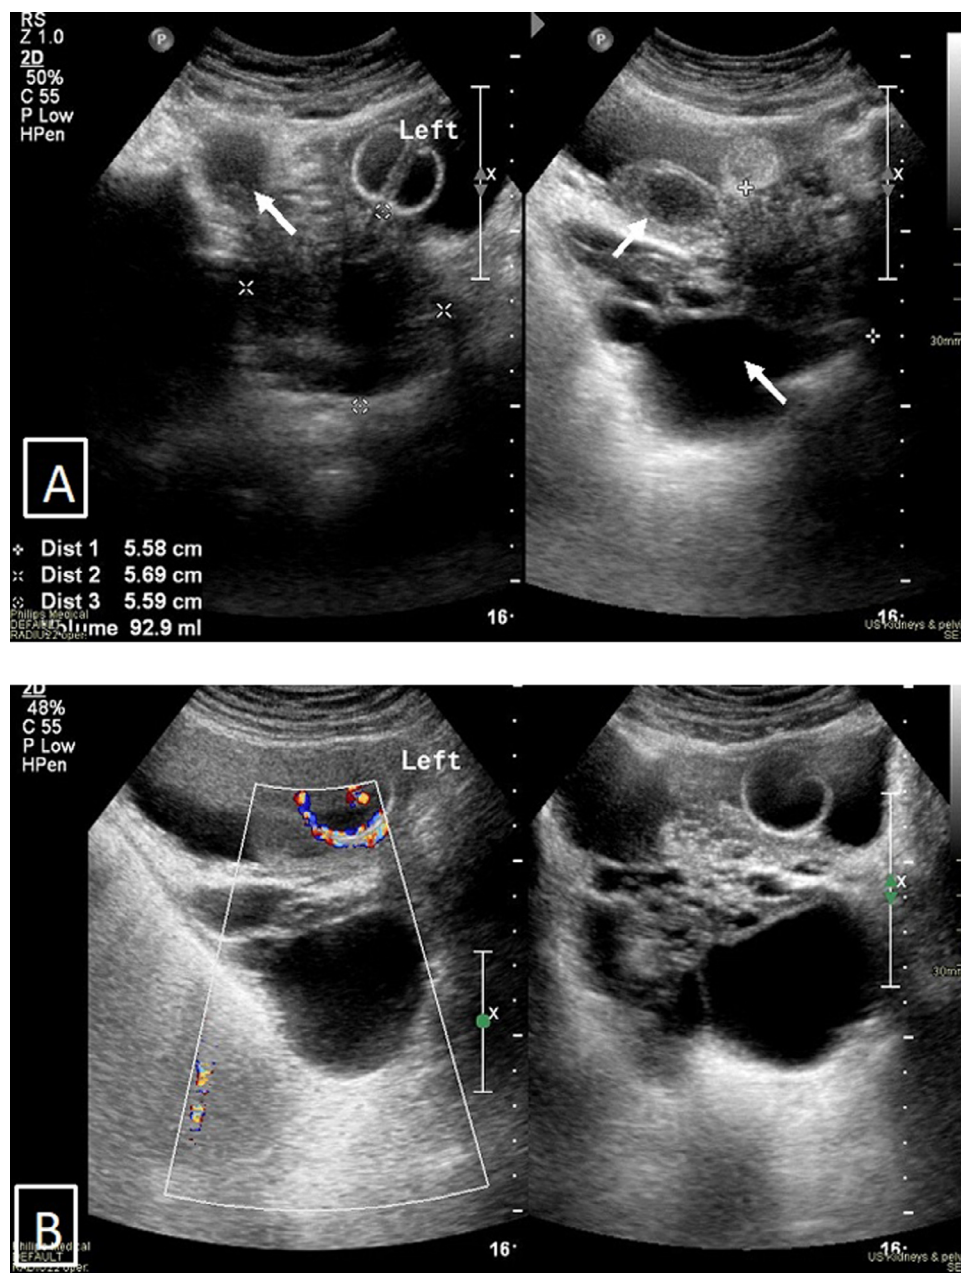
(A) A transabdominal ultrasound examination of the pelvis revealing the approximate contour of the prostate, measuring 5.58 x 5.69 x 5.59 cm, corresponding to a size of 93 mL. The prostate shows heterogeneous echotexture with multiple medium to large cystic components (arrows). The indwelling catheter balloon is noted within the bladder. (B) Color flow Doppler of the prostate and surrounding cystic lesion showing no blood flow in them consistent with being cystic in nature.
